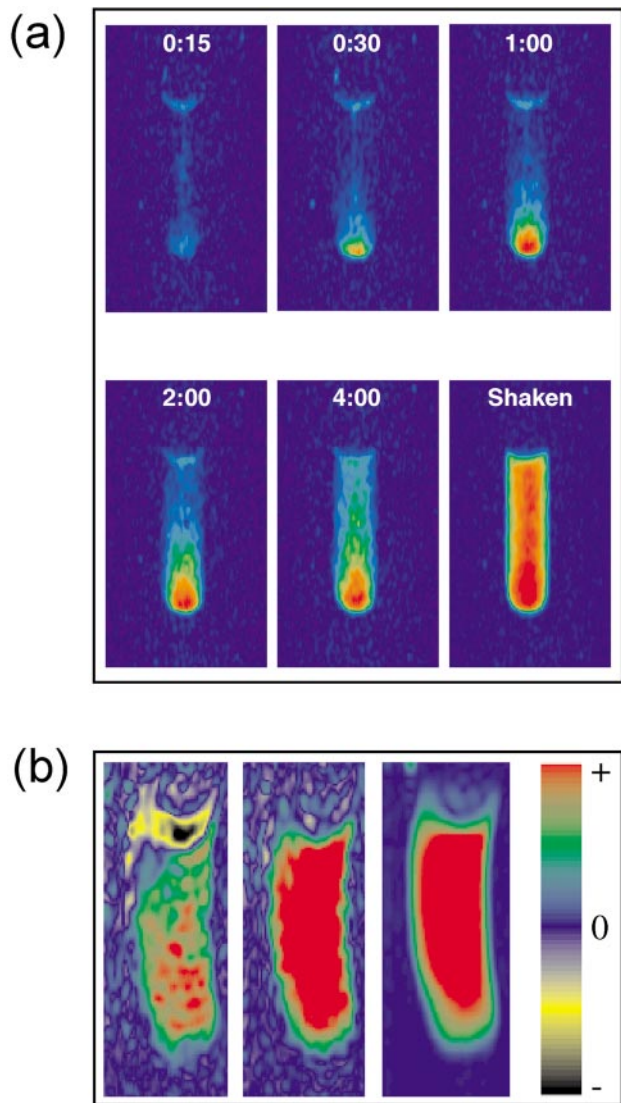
(Color) Time-dependent OPMRI of laser-polarized xenon dissolving in benzene (103). The vertical axis of the images is parallel to the external magnetic field and the long axis of the NMR sample tube. (a) Time-resolved false-color 2D FLASH ^{129}Xe MR images of the dissolved xenon in a sample tube containing partially deuterated benzene taken immediately following exposure to gaseous laser-polarized xenon. (b) The 2D false-color ^1H SPINOE MRI of fully protonated benzene taken 2 min (left image) and 6 min (middle image). Following the introduction of laser-polarized xenon; an equilibrium ^1H MR image is also shown (right image). The negative region in the left image (yellow/black region) originates from the expansion of the liquid phase of benzene following the dissolution of xenon. The images were obtained by the EPI method. The distortion of the images reportedly originated from inhomogeneity in the static magnetic field. Figures courtesy of Yi-Qiao Song.
